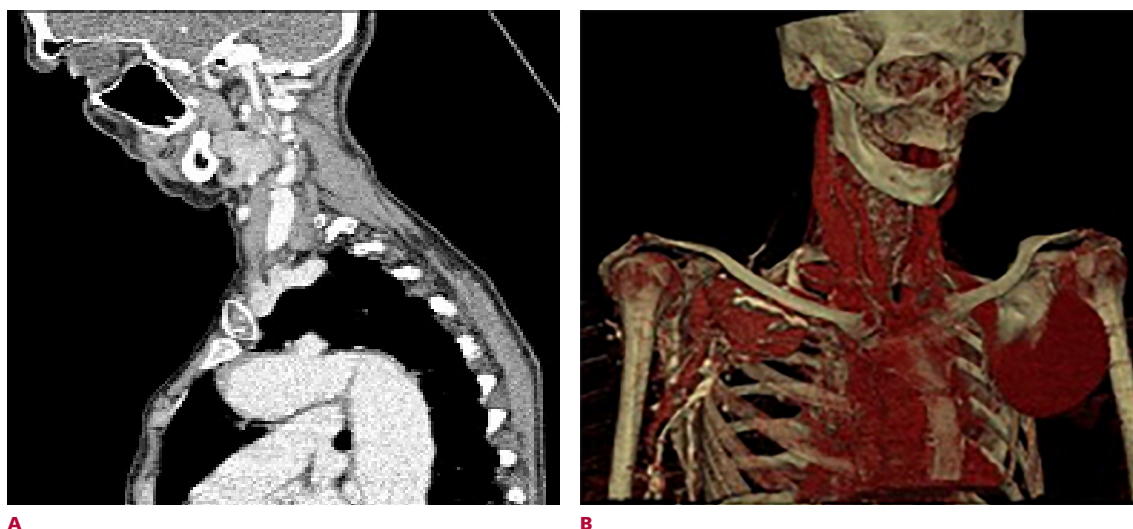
Computed tomography. A. Sagittal section showing dilation and coarctation of the aorta. B. Volumetric reconstruction showing both aneurysmal dilations of the subclavian arteries
